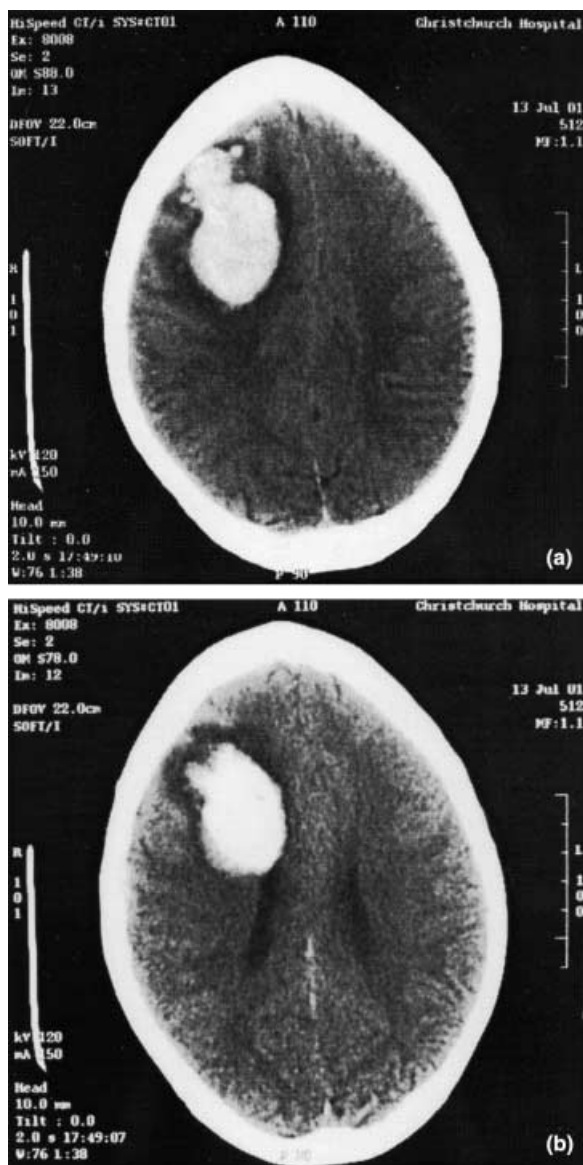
CT scan done on day 8 of admission showing extensive haemorrhage in the right frontal lobe with intraventricular extension.
